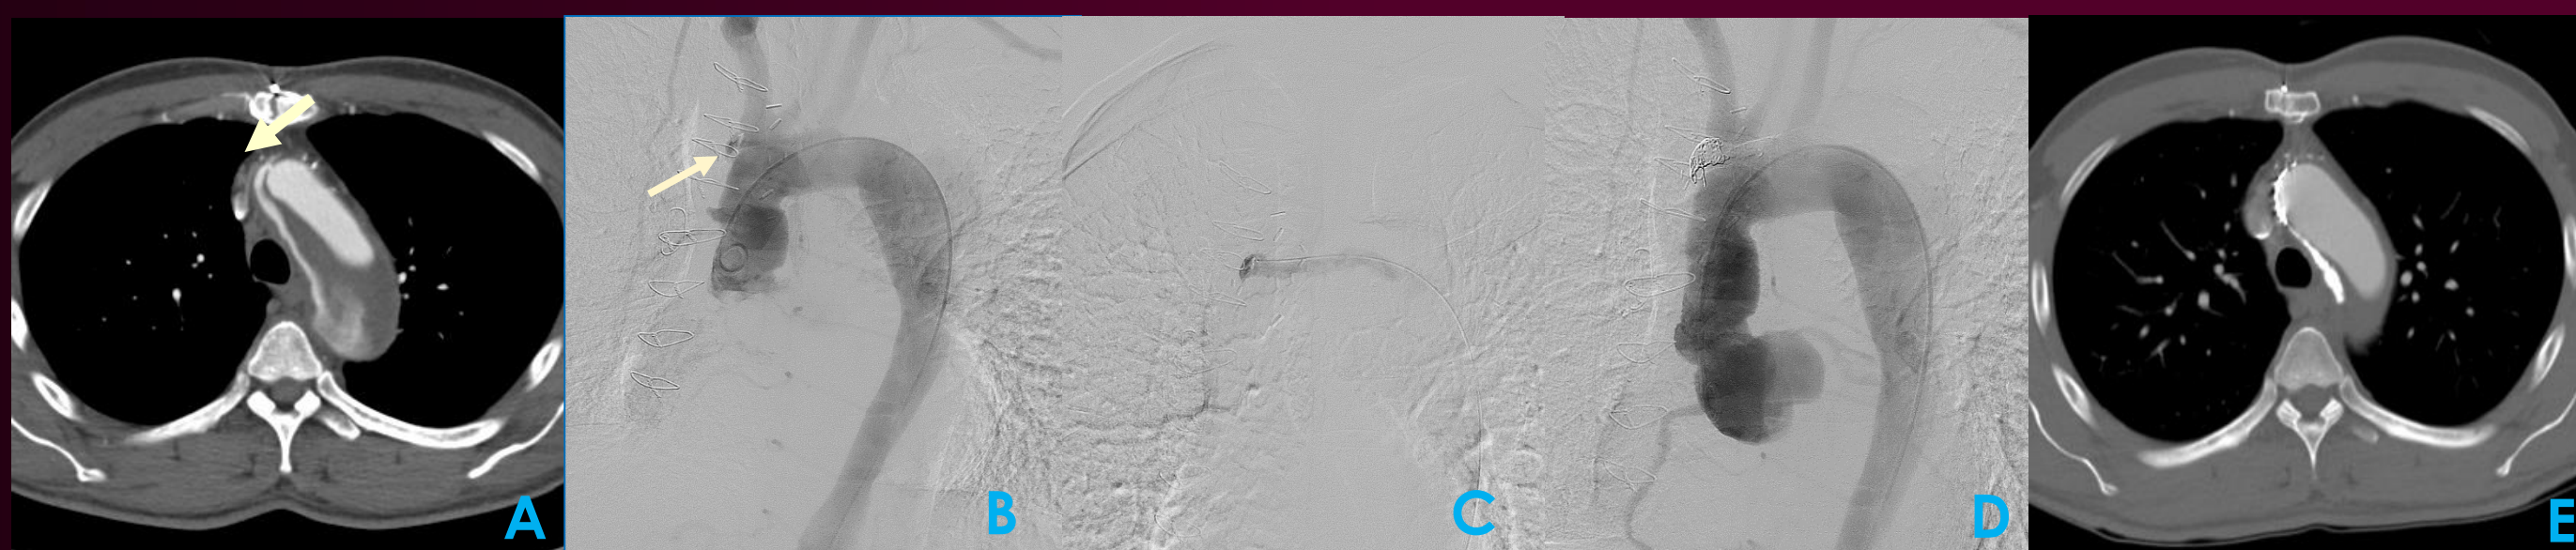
A. Contrast-enhanced CT image obtained 5 days after ascending aortic replacement shows contrast leakage in to the false lumen in the aortic arch (arrow).
